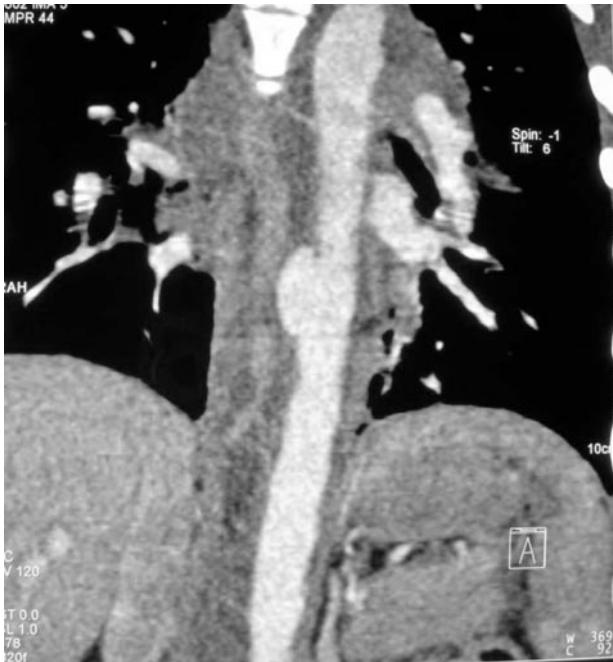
CT scan: rupture of retrocardiac thoracic aorta.
